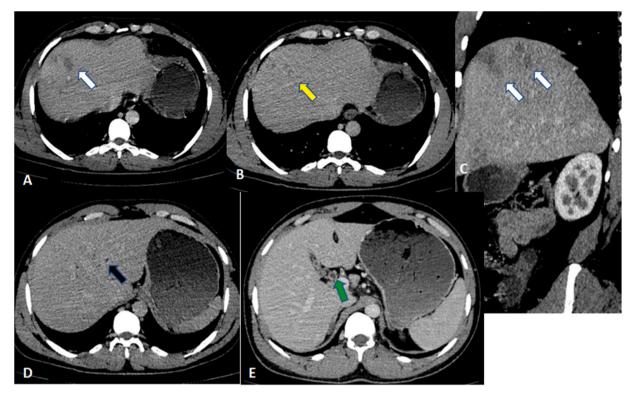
Multiphasic abdominal CT images at the liver level: Post-contrast axial (A, B, D & E) and coronal (C) images of a patient with Fasciola hepatica. The scans show peripheral subcapsular region multifocal, ill-defined, hypoattenuations in the right hepatic lobe (white thick arrows) which showed progressive contrast filling in the delayed phase (yellow arrow). The axial images also display mild intrahepatic biliary duct dilatation (black arrow) and common hepatic duct wall thickening (green arrow).
